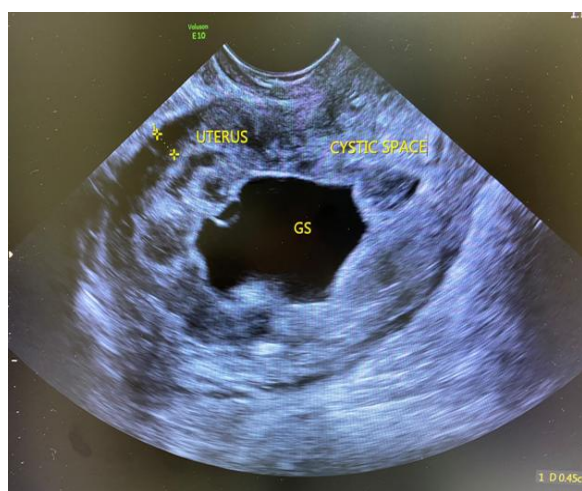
A transvaginal ultrasound showing the empty gestational sac
